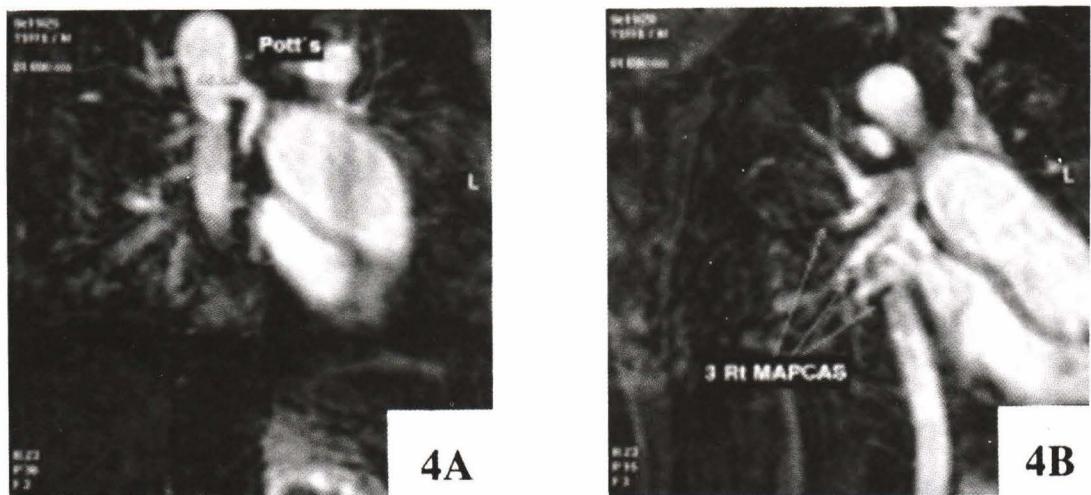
Cardiac MRI demonstrated 3D-imaging using of gradient echo small left pulmonary artery from descending aorta to Pott's shunt (A) and three collateral vessels from descending aorta (B).
